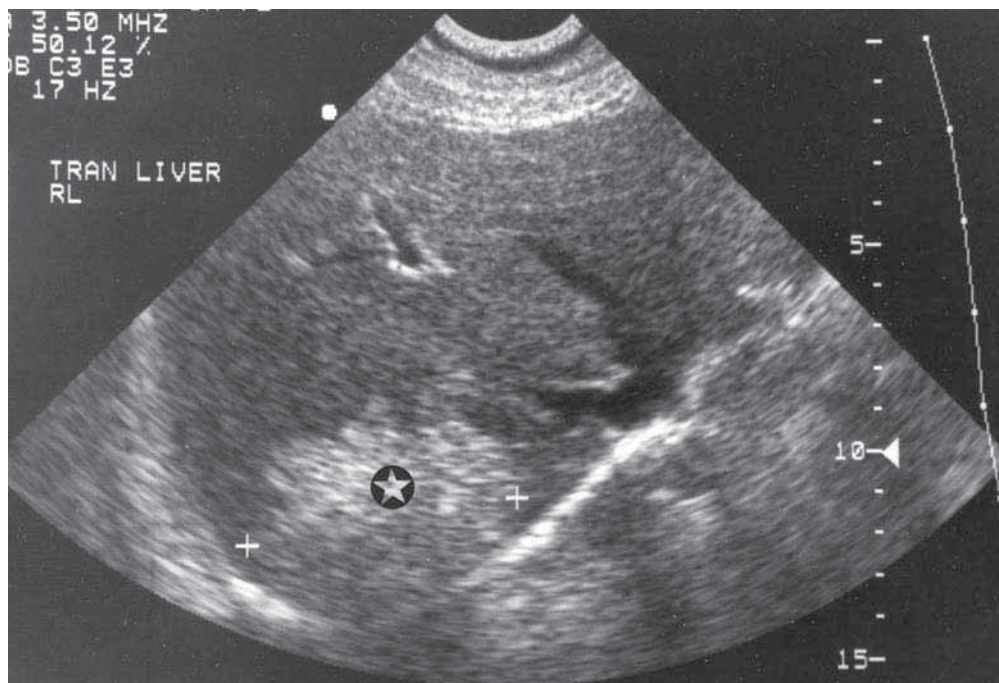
Transverse Ultrasound of Abdomen Showing a Tumor Mass in the Liver
